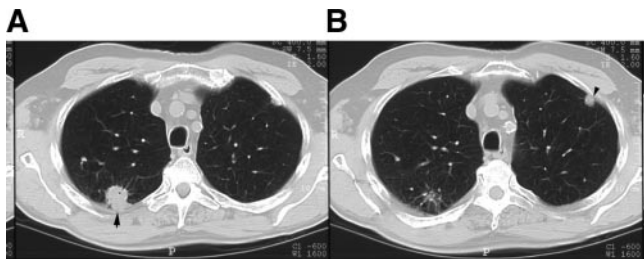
CT scans of the chest show a 2.3-cm pleural-based speculated mass in the right lobe posterior segment (A, arrow) and a 0.6-cm pleural-based mass in the left upper lobe anterior segment (B, arrow).
